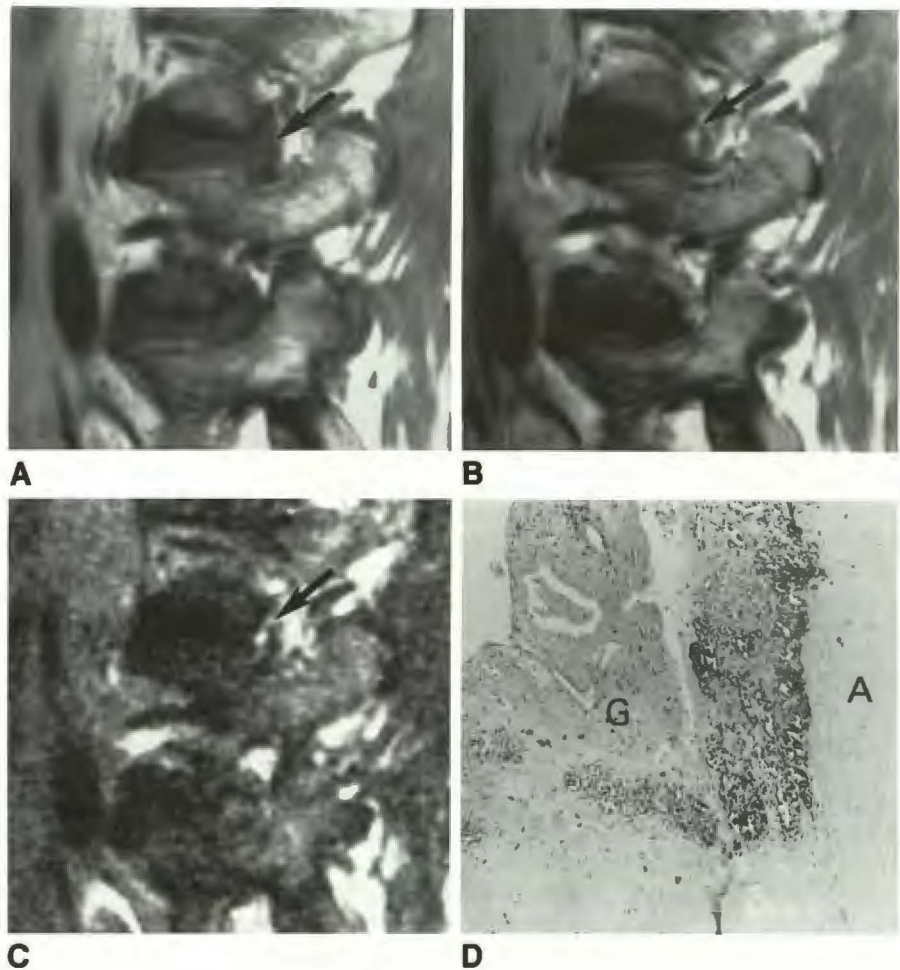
A–C, Anular tear on T1-weighted images before (A) and after (B) contrast and on T2-weighted image (C). Type II tear pattern (arrows) is seen as globular increased signal intensity within lateral L3–L4 annulus on T1-weighted images (A and B). Tear is seen as high signal intensity within low-signal-intensity annulus on T2-weighted image (C). At surgery, granulation tissue was present within annulus, without focal herniation.
